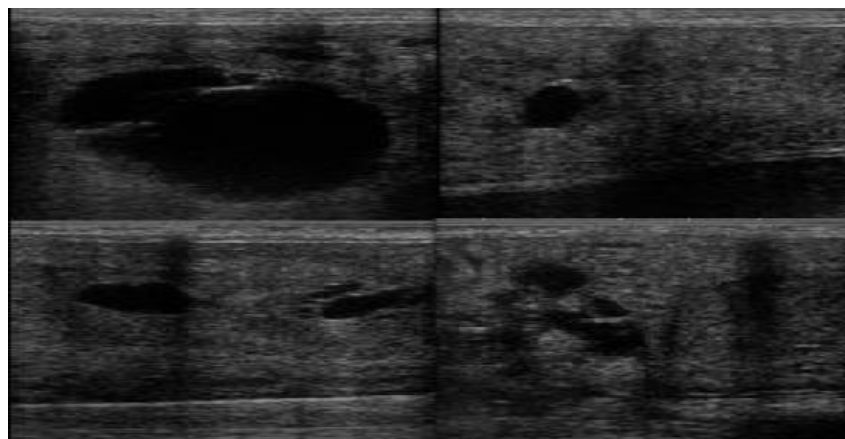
Ultrasound Images of Varied Uterine Cysts.
